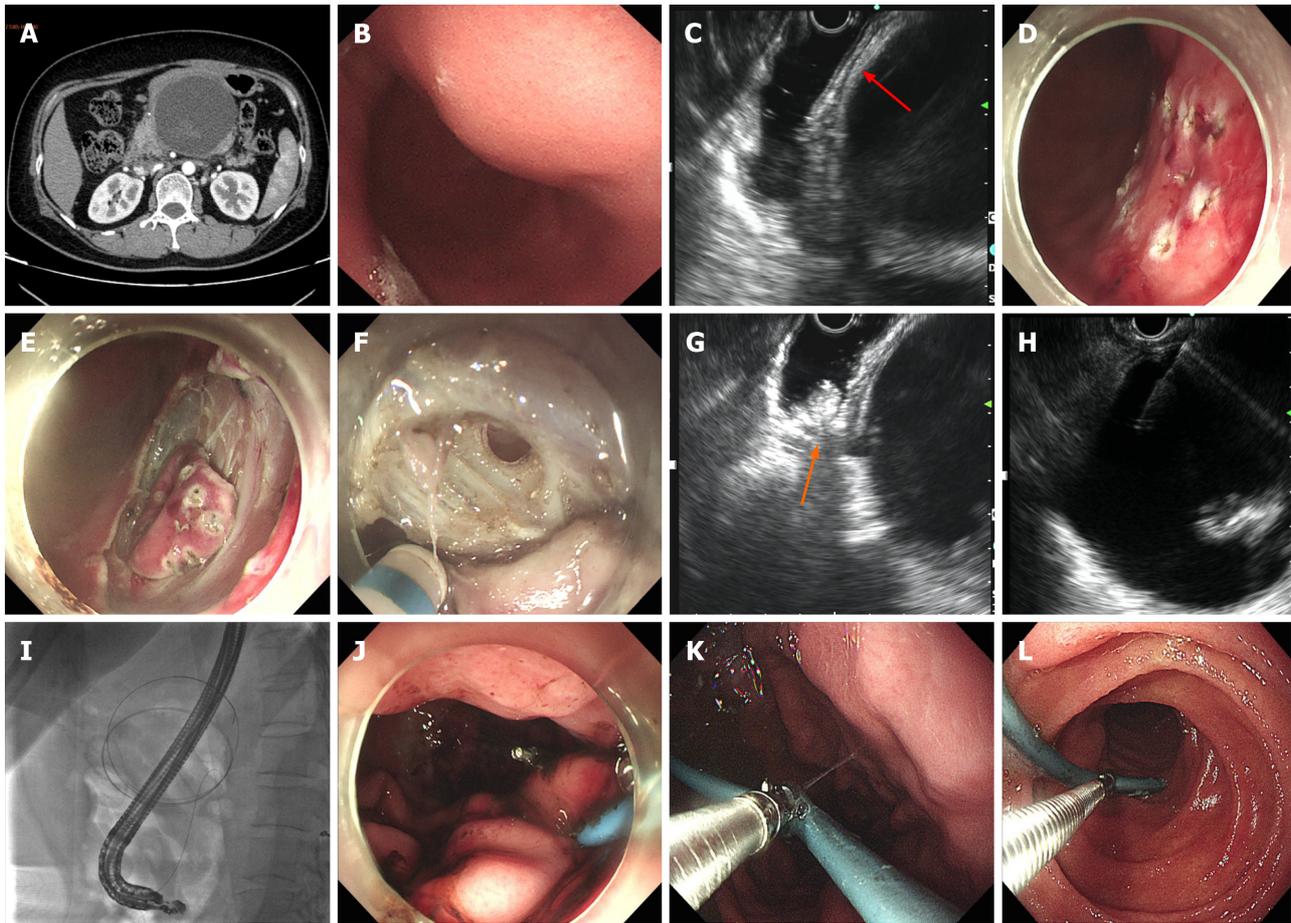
Case 1 (failed fenestration) with indwelling nasal-cyst drainage tube. A: Closely connected walled-off necrosis (WON) and gastric wall (preoperative computed tomography scan); B: Smooth, compressive indentation of stomach by WON; C: Endoscopic ultrasound (EUS) showed closely connected WON and gastric wall (with clear layers, red arrow); D and E: Incising the selected sites layer by layer by an endoscopic submucosal dissection approach; F: Nonadherence of WON and stomach after incising gastric muscularis propria; G: WON mobilization far from fenestration site (orange arrow) under EUS guidance; H: Needle puncture into WON from gastric wall; I: Visible separation of WON and stomach by X-ray fluoroscopy after inserting the guidewire into WON; J: Indwelling nasal-cyst drainage tube passed through the stomach into WON and closing the incised gastric muscularis propria by metal clips; K and L: Nasal-cyst drainage tube was cut off and we reverted to internal drainage 15 d later.
